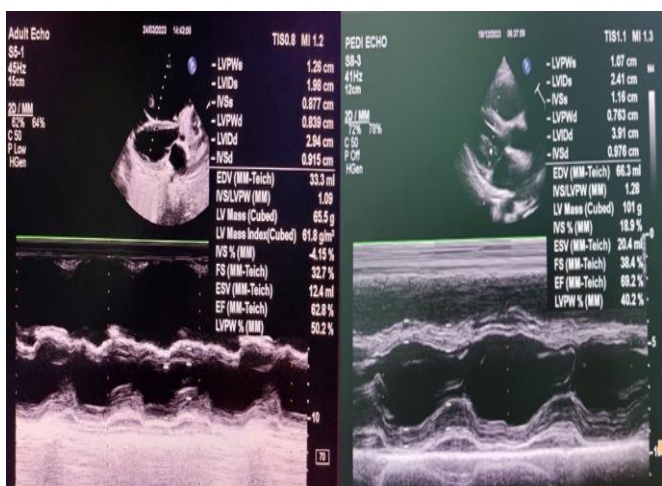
Echocardiography; Increased LV Function
